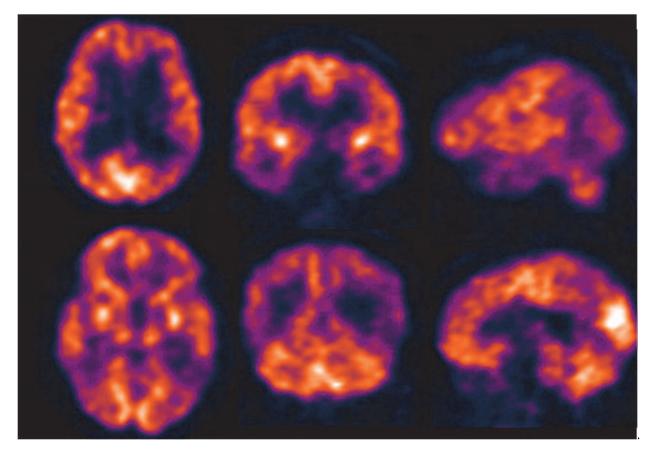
PET in AD. Transversal, coronal and sagital slices of a cerebral 18F-FDG study of a patient with mild cognitive impairment. Hypometabolism of bilateral temporal and parietal cortex including part of the posterior cingulate gyrus (left dominance) was observed, corresponding to incipient AD.
